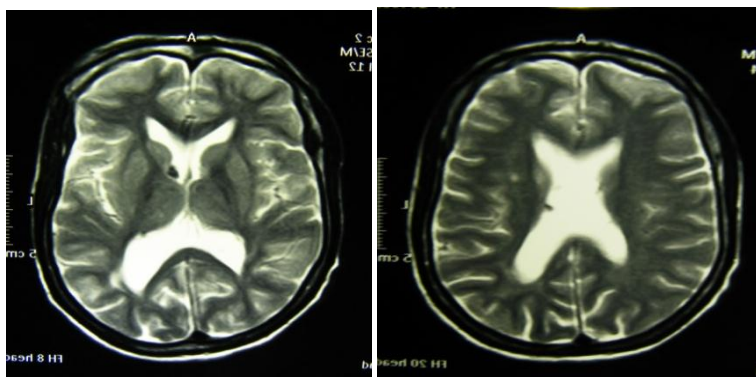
MRI – head (T2 and FLAIR) Sub-ependymal calcification.
